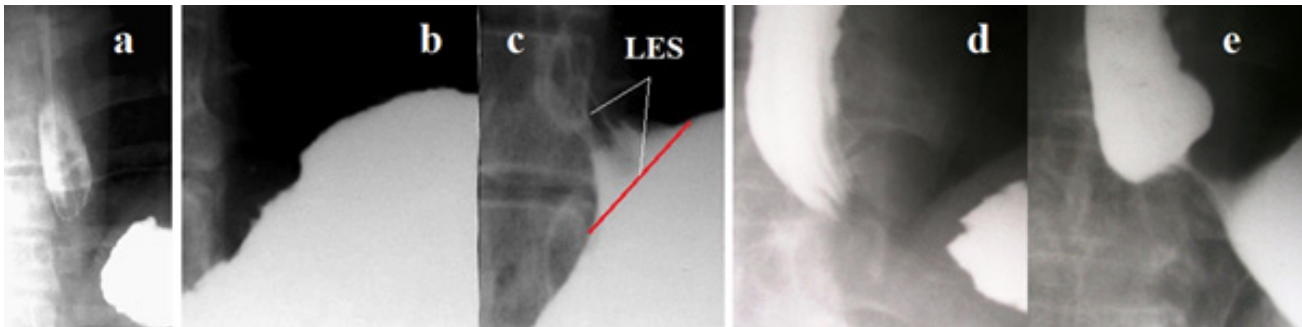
Radiographs of the esophagogastric junction in patients GERD with abdominal compression during barium intake. (a). A gap without contrast is seen between the esophagus and stomach due to contraction of the LES in response to increased pressure in the stomach. Longitudinal folds in the LES and esophagus indicate esophagitis. (b-c). After filling the stomach with barium (b). During the water-siphon test, barium refluxed into the esophagus due to wide opening of the intra-abdominal portion of the LES – angular deformation above the red line (c). (d). Study of the patient before and (e) during abdominal compression. Abdominal compression caused a sharp shortening of the LES with angular deformation of the image because of opening of the intra-abdominal portion of the LES.
